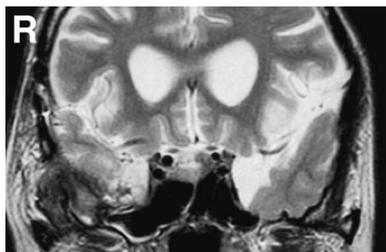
Coronal T₂-weighted magnetic resonance image obtained 1 month after surgery showing disappearance of the temporal encephalocele and cerebrospinal fluid collection in the right sphenoid sinus.
